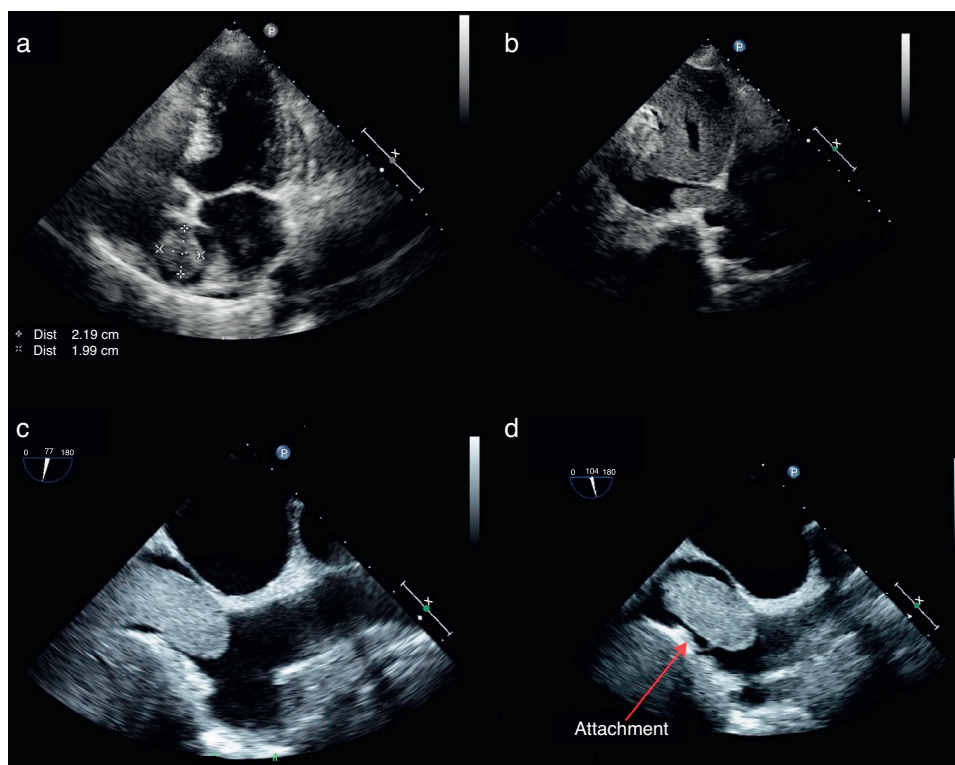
(a) Transthoracic echocardiography, apical 4-chamber view, showing a homogenous ovoid mass; (b) transthoracic echocardiography, subcostal view, showing the mass extending from the inferior vena cava to the right atrium; (c) transesophageal echocardiography, off-axis bicaval view, showing invasion of the inferior vena cava; (d) transesophageal echocardiography, bicaval view, showing the thin attachment of the mass to the right atrial inferoposterior wall.
